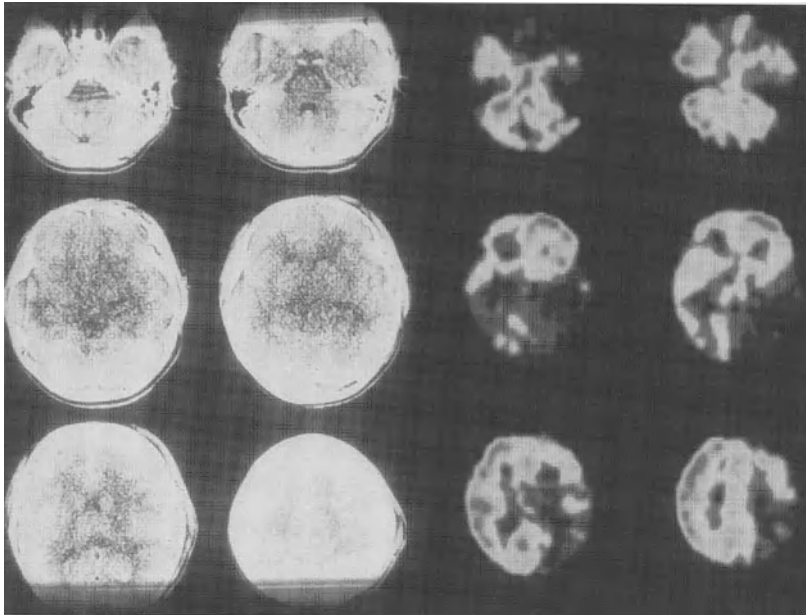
Computed tomographic scan (*left*) and Single photon emission computed tomography scan (*right*) of patient after head injury
